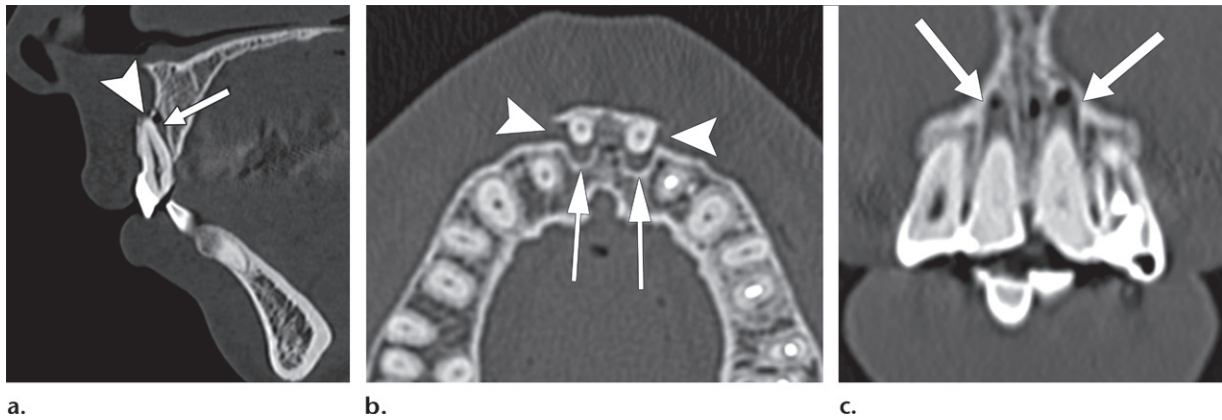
Dental lateral luxation. Sagittal (a), axial (b), and coronal (c) CT images (bone window) show tooth displacement, widening of the PLS (arrows), and fracture of the alveolar process (arrowheads in a and b).
